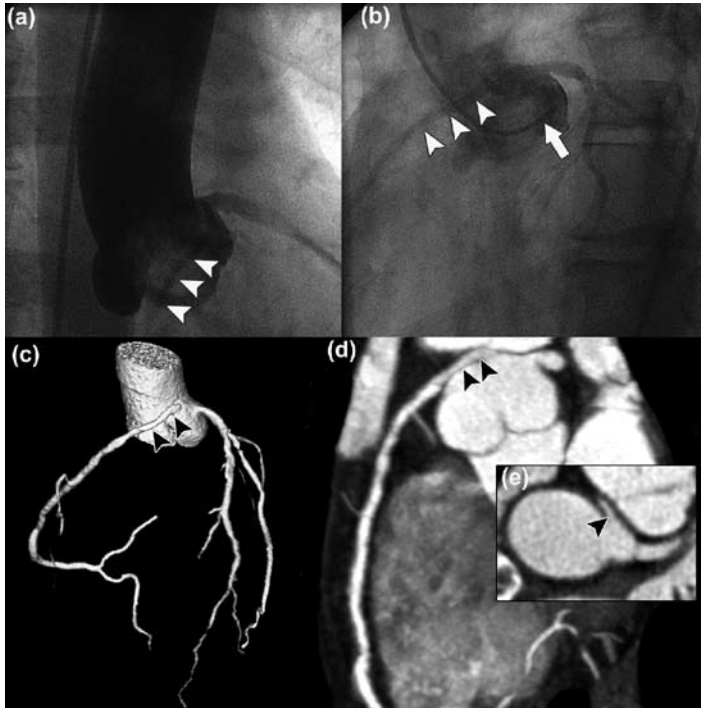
Anomalous origin of the right coronary artery (RCA). (a) An aortogram was performed to localize the origin of the RCA, whose contours are faintly visible (arrowheads). (b) Non-selective injection confirms its origin (arrowheads) out of the left coronary cusp. (c, d, e) CT coronary angiogram clearly showing the anomalous origin (arrowheads) and course of the RCA
